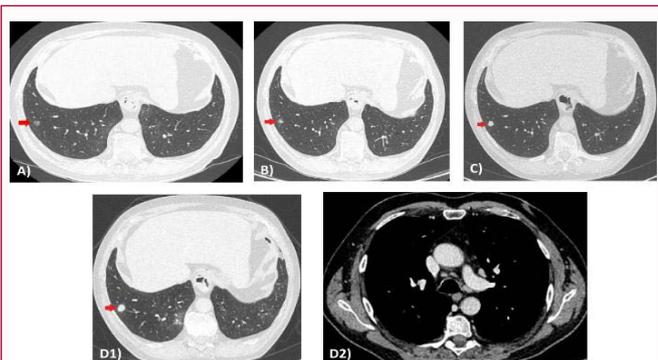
A) Chest computed tomography showing the evolution of the nodule in the right lower lobe over 2016, B) 2017, C) 2018 D) 2019 D2 (mediastinal window) with subcarinal lymphadenopathy.
